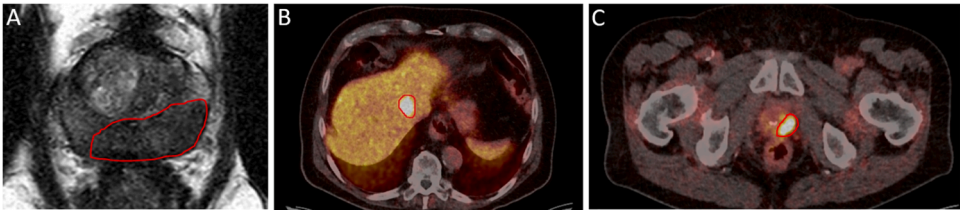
A) mpMRI of the prostate before the biopsy - extensive radiological changes of the prostate in the peripheral zone (red outline), making it hard to distinguish between severe inflammation (prostatitis) and potential prostate cancer; B) 68Ga-PSMA PET/CT – a soft, well-supplied liver lesion in segment IVa (red outline) (confirmed as cholangiocellular carcinoma); C) 68Ga-PSMA PET/CT - malignancy-typical hypermetabolism (red outline) of the known primary prostate tumor.
